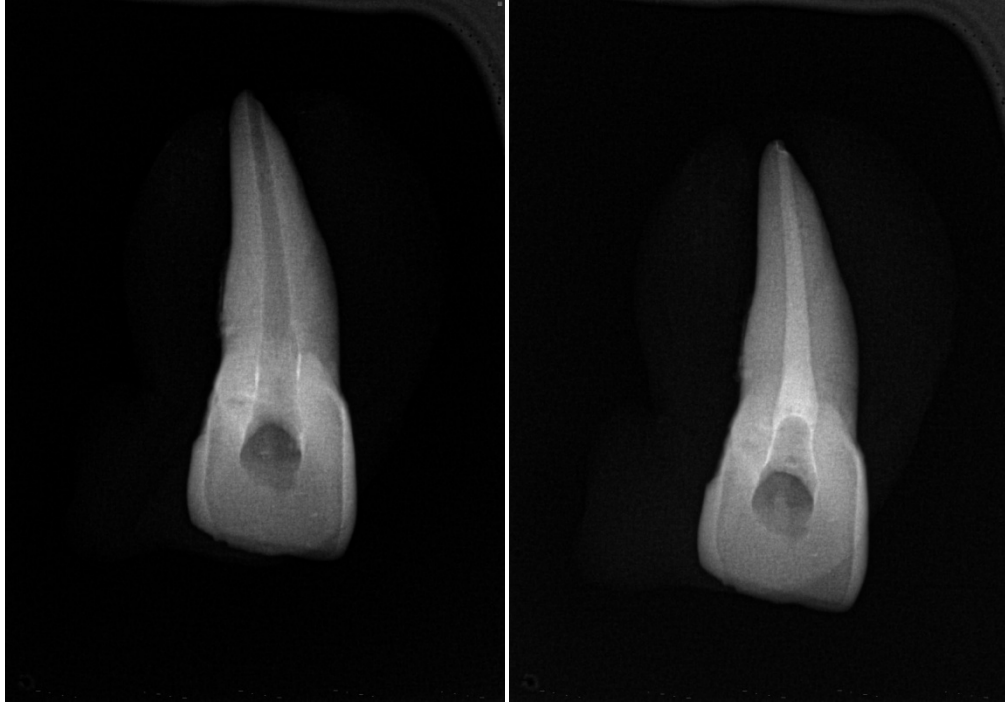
Radiograph of tooth filled with original DAP (left) and radiograph of tooth filled with RoDAP (right).
